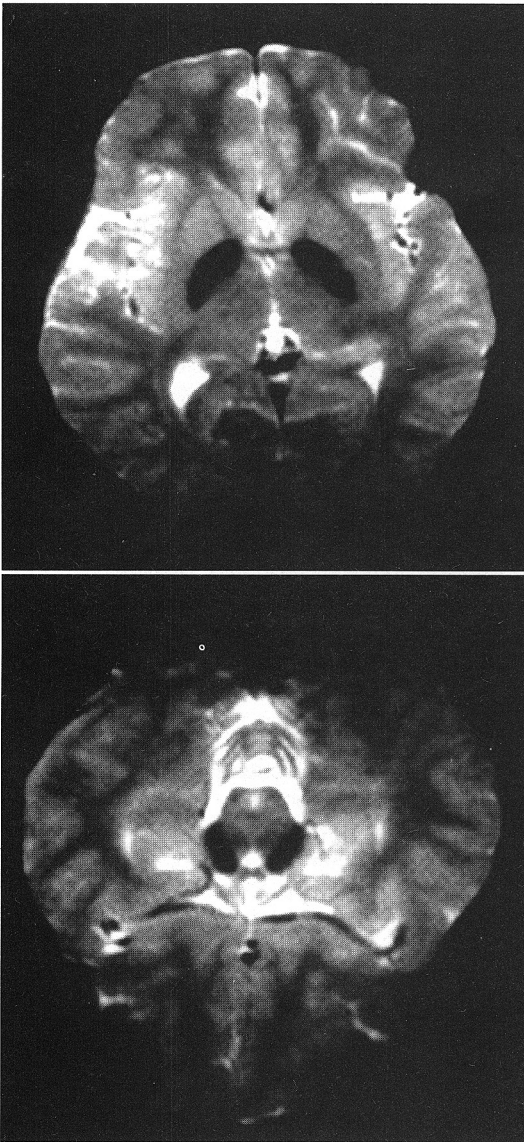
Magnetic resonance scan T2-weighted images (2.0 T) of patient 1 shows prominent low signal intensities bilaterally in the globus pallidus and the substantia nigra.
